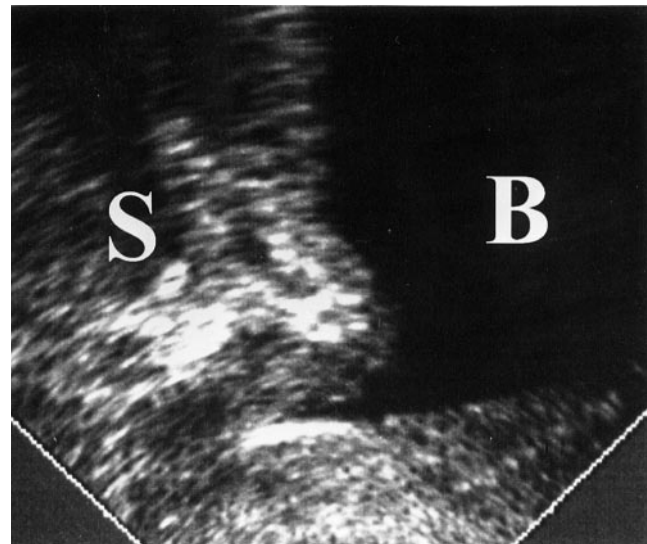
Sagittal introital ultrasound image of the pelvis, showing funneling of the proximal urethra during a Valsalva maneuver. S, symphysis; B, bladder.
